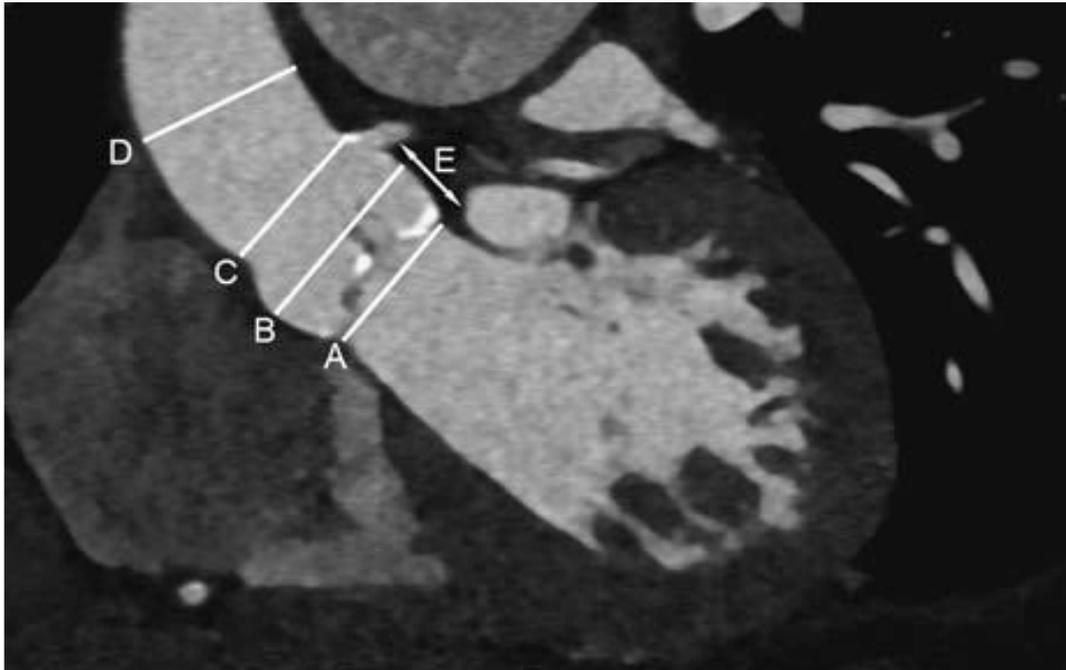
Overview of standard measurements on cardiac CT for TAVR assessment on coronal-oblique multiplanar reformations along the axis of the aortic root. A, Diameter of the AA. B, Sinus of Valsalva. C, Sinotubular junction. D, Ascending aorta. E, Distance between AA and left coronary artery ostium.
